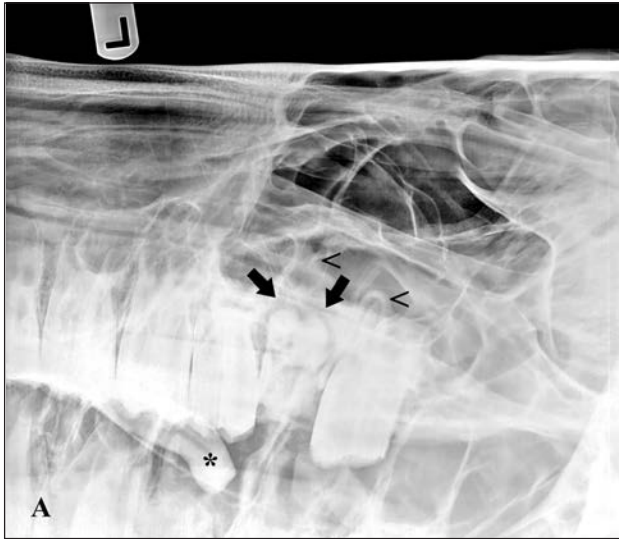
Same radiographic views as in Figure 1. A—In the right 30° dorsal-left ventral oblique view, a smooth-bordered, radiopaque structure approximately 65 mm in length with a linear central radiolucency (asterisk) is located in the region demarcated by the left maxillary third premolar and first molar teeth. The left maxillary second molar tooth has a complicated crown root fracture with widening of the periodontal ligament space; the roots have a blunted appearance (black arrows). Condensing osteitis (sclerotic periapical alveolar bone), thickening of the sinus epithelium, or both is present around the roots of the left maxillary second molar tooth, the mesiobuccal root of the left maxillary third molar tooth, and the rostroventral floor of the caudal maxillary sinus (carets). B—In the right 50° ventral-left dorsal oblique view, the same radiopaque structure as in panel A (asterisk) is projected over the crowns of the right mandibular cheek teeth. The left maxillary cheek teeth are projected in the space between the quadrants. Blunting of the roots of the left maxillary second molar tooth (black arrow) and periapical condensing osteitis (caret) are evident. C—In the dorsoventral radiographic view, the same radiopaque structure (asterisk) is seen lying buccal to the cheek teeth. There is a radiolucent area in the center of the second molar tooth (black arrow), which is likely due to the loss of clinical crown or infundibular caries. Condensing osteitis of the alveolar bone associated with the left third molar mesiobuccal root is evident (caret). The small radiopacity superimposed on the left mandibular second premolar tooth is a metal part of the bungee cord used to hold the radiography cassette in place.
